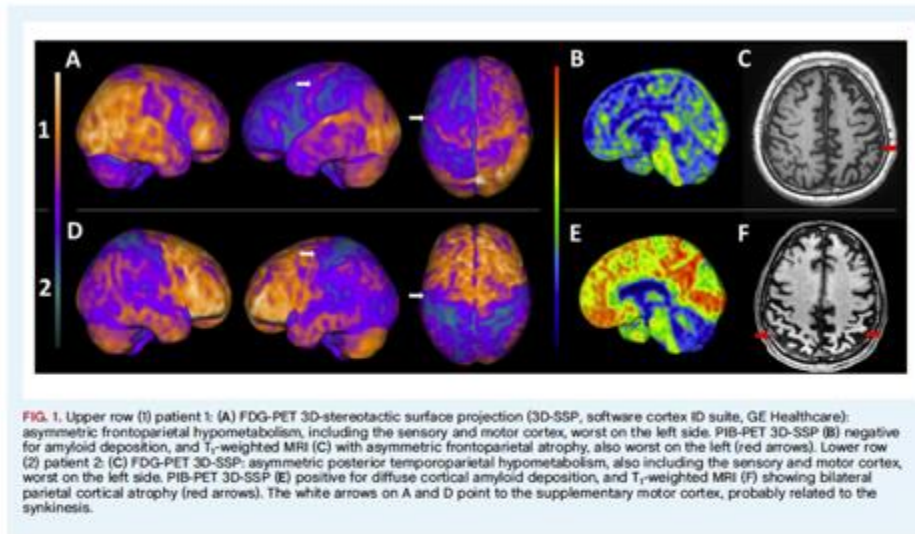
Upper row (1) patient 1: (A) FDG-PET 3D-stereotactic surface projection (3D-SSP, software cortex ID suite, GE Healthcare): asymmetric frontoparietal hypometabolism, including the sensory and motor cortex, worst on the left side. PIB-PET 3D-SSP (B) negative for amyloid deposition, and T₁-weighted MRI (C) with asymmetric frontoparietal atrophy; also worst on the left (red arrows). Lower row (2) patient 2: (C) FDG-PET 3D-SSP: asymmetric posterior temporoparietal hypometabolism, also including the sensory and motor cortex, worst on the left side. PIB-PET 3D-SSP (E) positive for diffuse cortical amyloid deposition, and T₁-weighted MRI (F) showing bilateral parietal cortical atrophy (red arrows). The white arrows on A and D point to the supplementary motor cortex, probably related to the synkinesis.
